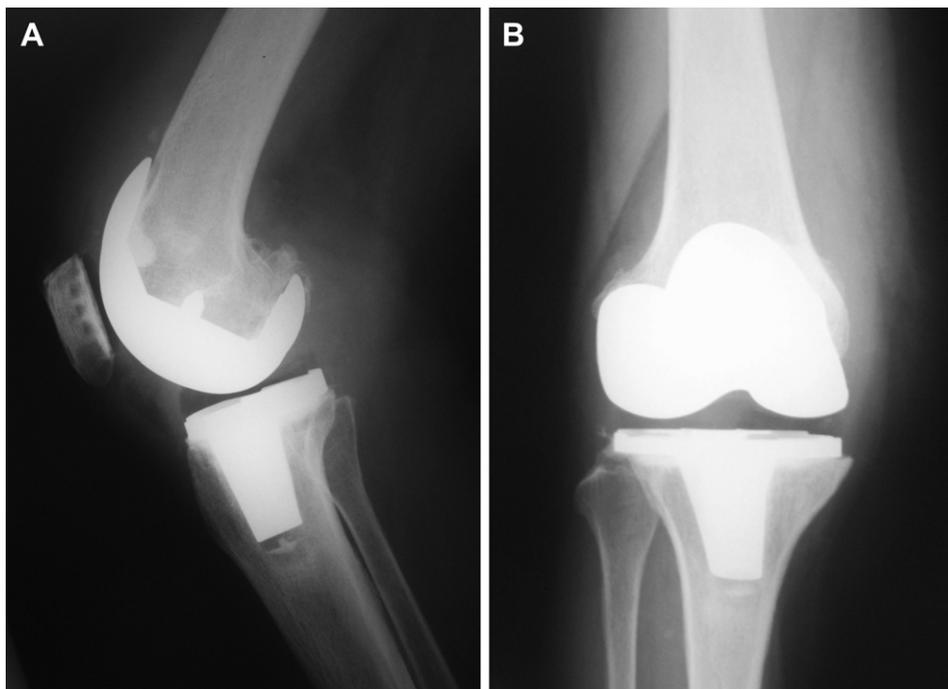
Postoperative X-rays after initial total knee arthroplasty.
